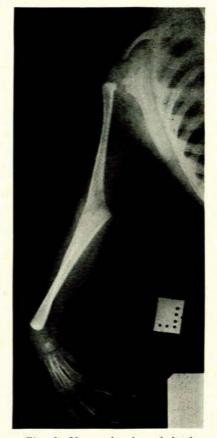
X-ray showing skeletal abnormalities of right upper limb (case 1).
